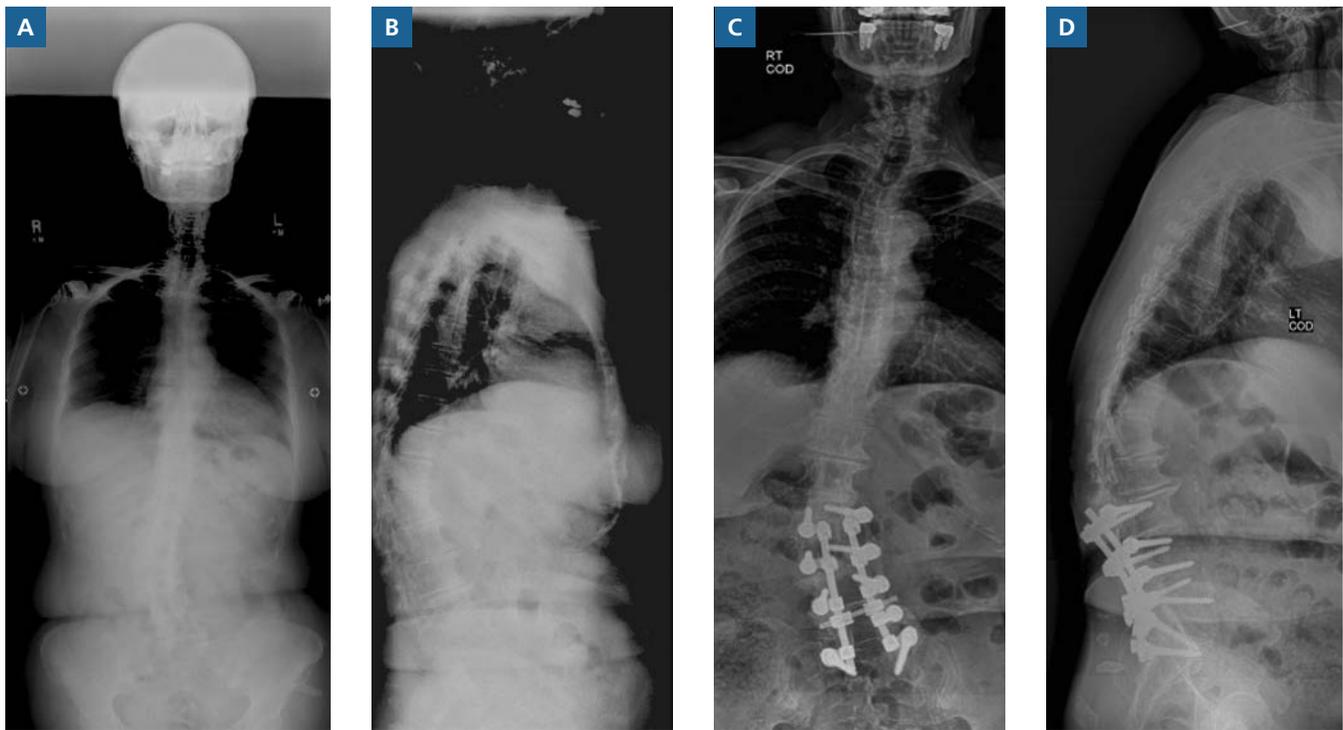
This 69-year-old female had progressive neurogenic claudication and back pain. A, Anteroposterior (AP) and B, lateral radiographic findings show a degenerative lumbar scoliosis. PI-LL mismatch preoperatively at 19°. L3 to S1 decompression and posterior spinal fusion of her lumbar curve with instrumentation reduced her PI-LL mismatch to 9°. Postoperative radiographs show resulting C, fractional curve and D, lumbar lordosis.
